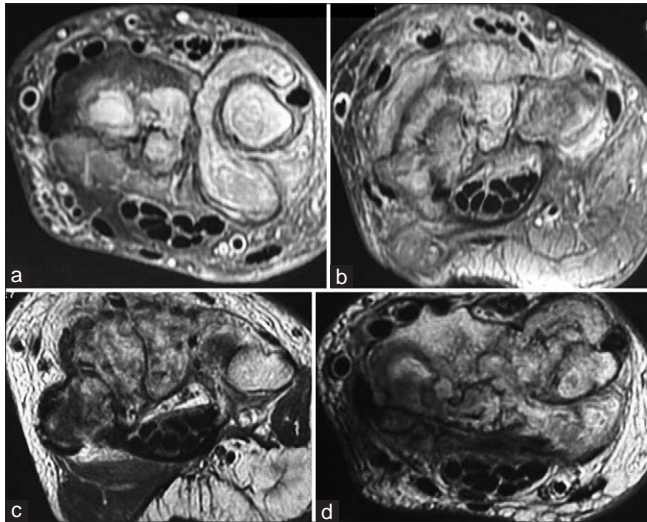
T2-weighted fat-saturated axial magnetic resonance imaging (MRI) (a and b) and T2-weighted images MRI, (c and d) show the dorsal to the volar extension of the lesion around the distal ulna with diffuse erosions into the medullary cavity of the radius and ulna
